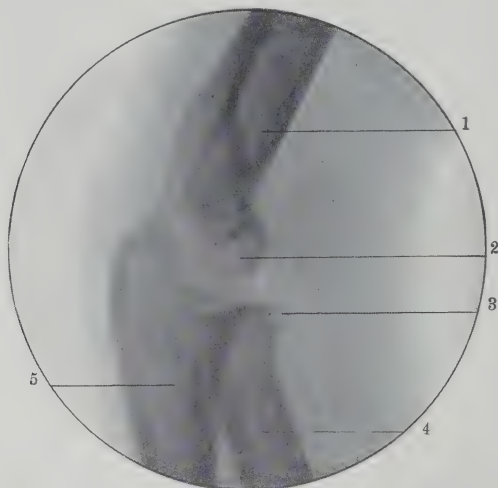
Radiograph Showing Lateral View of Elbow at Eleven Years. (Variation.) 1, Humerus; 2, capitellum; 3, upper epiphysis of radius; 4, radius; 5, ulna. (Original.)
